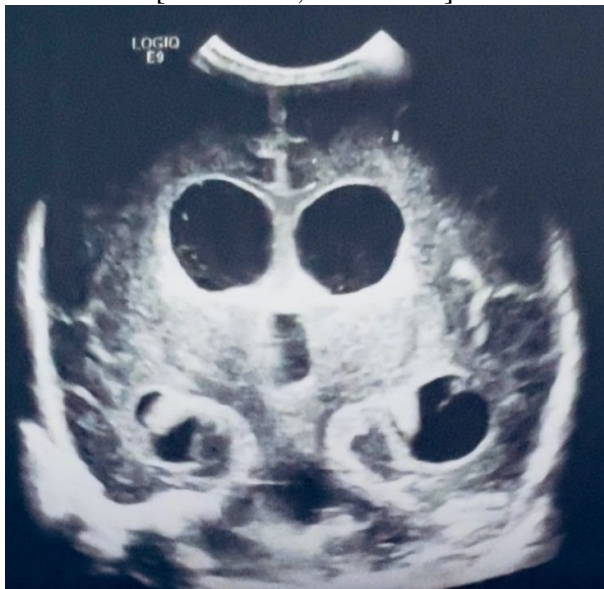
TRANSFONTANELLAR ULTRASOUND CORONAL SECTION
